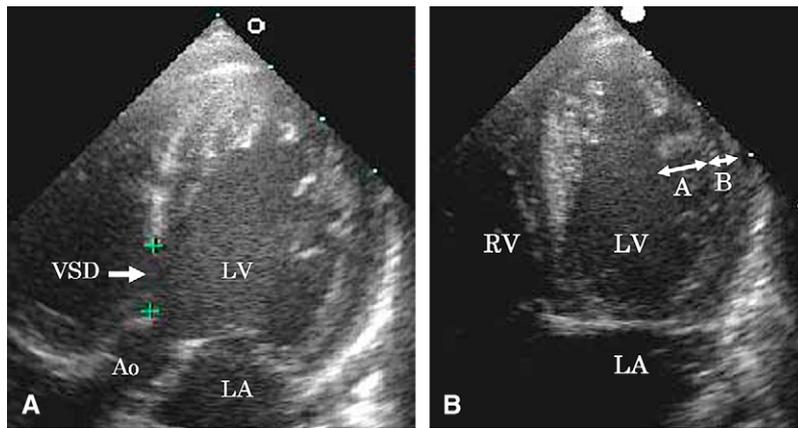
A, Four-chamber view of echocardiogram shows a large perimembranous inlet VSD. Distinct trabeculations are recognized in the apical and mid-lateral segments inside the left ventricle. B, Another 4-chamber view of echocardiogram. There are prominent trabeculations and deep intertrabecular recesses in the apex and mid-lateral of left ventricle. *Arrow A* shows the distance from the peak of prominent trabeculations to intertrabecular recesses: the noncompacted layer. *Arrow B* shows the distance from the epicardium to the intertrabecular recesses: the compacted layer. This case satisfies the diagnostic criterion for LVNC that the length of *A* must be greater than double the length of *B*.¹ *Ao*, Aorta; *LA*, left atrium; *LV*, left ventricle; *VSD*, ventricular septal defect; *RV*, right ventricle.
